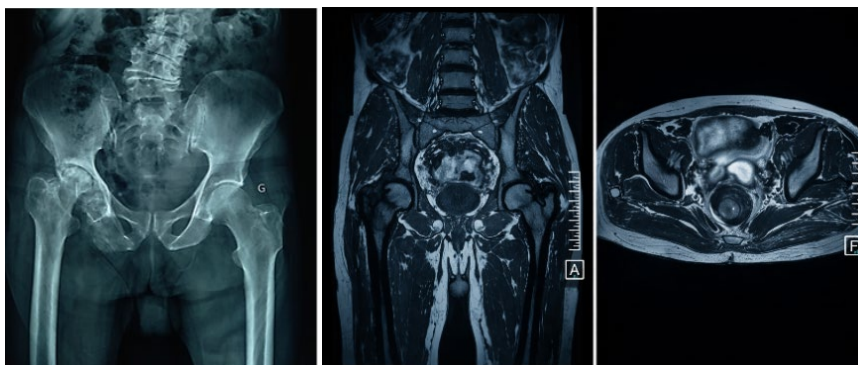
Pelvic radiograph demonstrating secondary hip osteoarthritis with erosions of the femoral head. Magnetic resonance imaging (MRI) revealed hip joint effusion associated with a right gluteal fluid collection.
